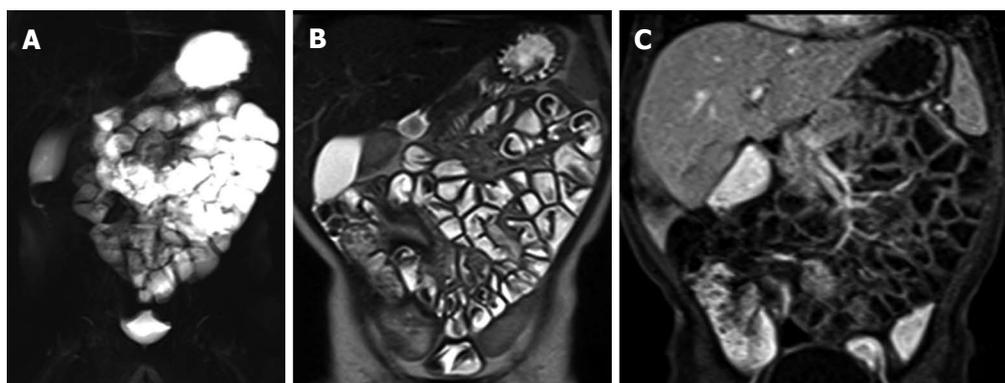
Magnetic resonance enteroclysis under anesthesia in one-year old male with Crohn's disease at colonoscopy. Coronal thick-slab HASTE image (A) shows good opacification of proximal and distal small bowel. The coronal T2-weighted (T2-w) image (B) and coronal fat-suppressed (FS) three-dimensional (3D) T1-weighted (T1-w) breath-hold gradient-echo (GE) image (C) are performed in free breathing.
